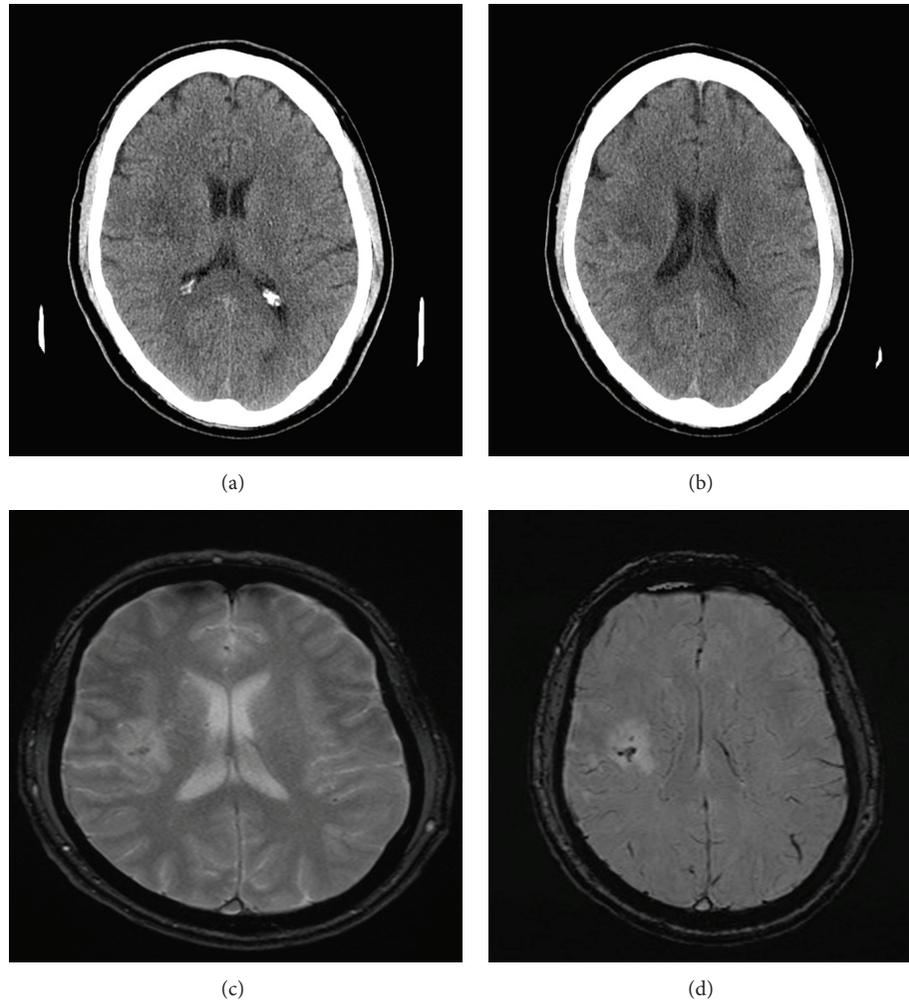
Subject presented with mild left hemiparesis. The day one CT (a) and (b) shows a small infarct in the right subcortical white matter, with a suggestion of increased signal within the central portion. The gradient echo (c) and susceptibility weighted image (d) MRI sequences performed on day seven suggest a small amount of blood within the infarct. No clinical deterioration was detected.
